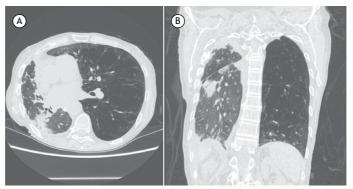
Pulmonary tuberculosis in a 48-year-old man who underwent right lung transplantation. Axial and coronal HRCT scans (A and B, respectively), showing diffuse pleural thickening, peripheral linear opacities, and consolidation in the superior segment of the right lower lobe of the right lung. Note the increased volume of the left lung, due to extensive panacinar emphysema.
